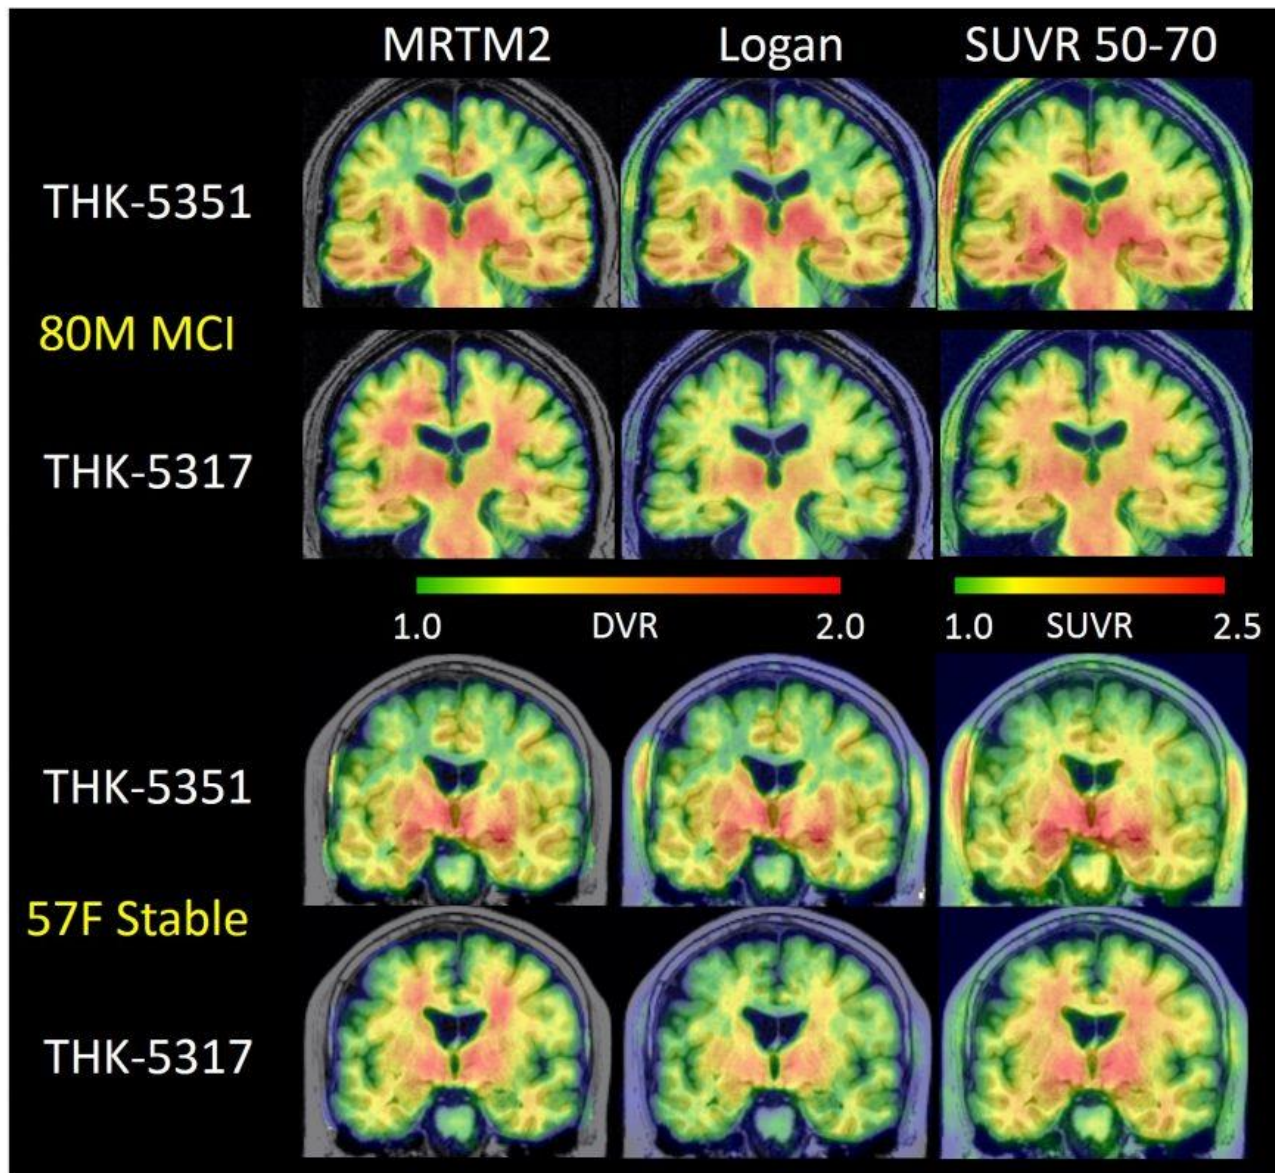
Comparison of parametric THK-5351 and THK-5317 DVR and SUVR images. Differences were most predominant in WM for THK-5317 where MRTM2 and SUVR methods showed higher signal compared to Logan. DVR and SUVR methods for THK-5351 were generally in agreement. THK-5351 had higher binding estimates in gray matter regions associated with tau pathology compared to THK-5317.
